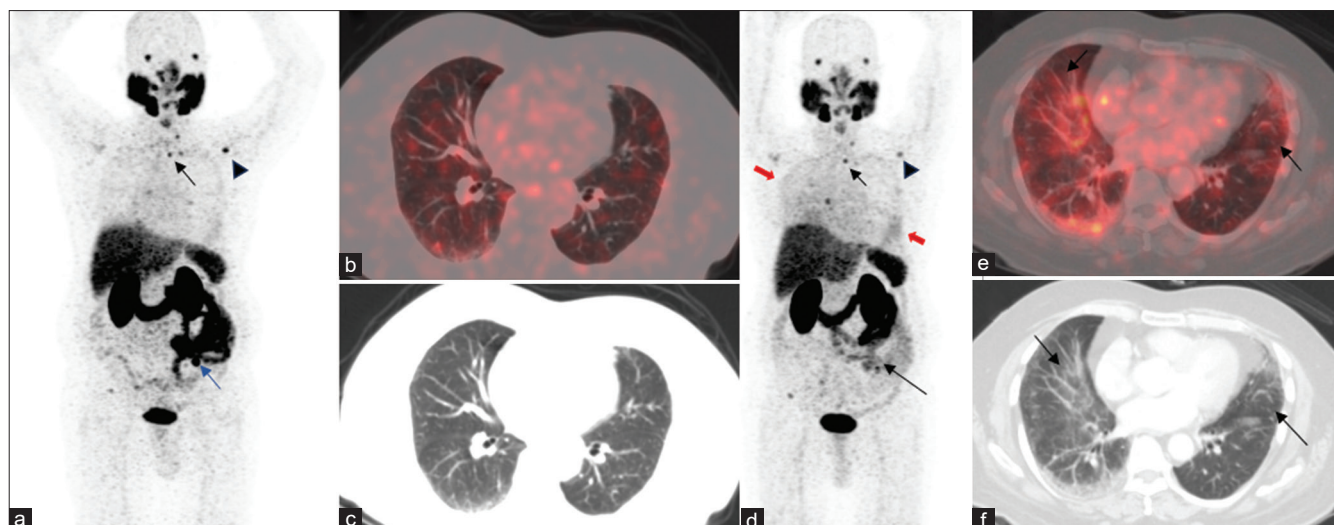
A 73-year-old man with metastatic castration-resistant prostate cancer, after 2 cycles of Lu-prostate-specific membrane antigen (PSMA) therapy and EBRT to the pelvis, was on enzalutamide treatment. He also complained of occasional shortness of breath. However, a pulmonary function test was not done. In view of rising serum PSA levels, the patient underwent Ga-68 PSMA positron emission tomography–computed tomography (PET/CT), which revealed PSMA expressing new skeletal lesions, with increased tracer avidity of preexisting skeletal lesions, indicating disease progression. Maximum intensity Projection (MIP) image (a) showed increased focal tracer in the left thoracic region, left shoulder region, and left pelvic region (Black arrow, left clavicle; black arrowhead, left scapula; blue arrow, left iliac bone), with no significant findings in bilateral lung fields (b and c). The patient was started on docetaxel chemotherapy, and PSMA PET/CT was repeated after 5 cycles of docetaxel for response assessment. On MIP image (d), focal tracer uptake was seen in the midline in the left thoracic, shoulder, and pelvic regions (black arrows, skeletal lesions), and diffusely increased tracer uptake (Red arrows) was seen in the thoracic region. Transaxial and coronal fused PET/CT (e) and corresponding CT image (f) show increased tracer uptake (SUVmax, 6.9) in ground-glass and reticular opacities and interstitial septal thickening, predominantly involving peripheral subpleural locations in bilateral lung fields indicating interstitial pneumonitis
